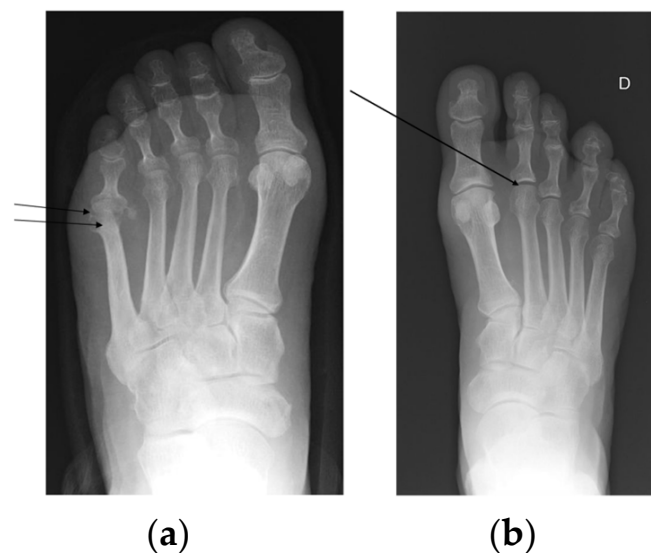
(a) A radiographic example of an osteomyelitis-positive case. The affected region is located at the fifth metatarsal. The observed radiographic signs include the loss of cortex with bony erosion and affected bone marrow (focal loss of trabecular pattern or marrow radiolucency). (b) A radiographic example of an osteomyelitis-negative case. The analyzed region is located beneath the second metatarsal head. No radiographic signs indicative of osteomyelitis, such as cortical disruption and medullary involvement, were observed.
